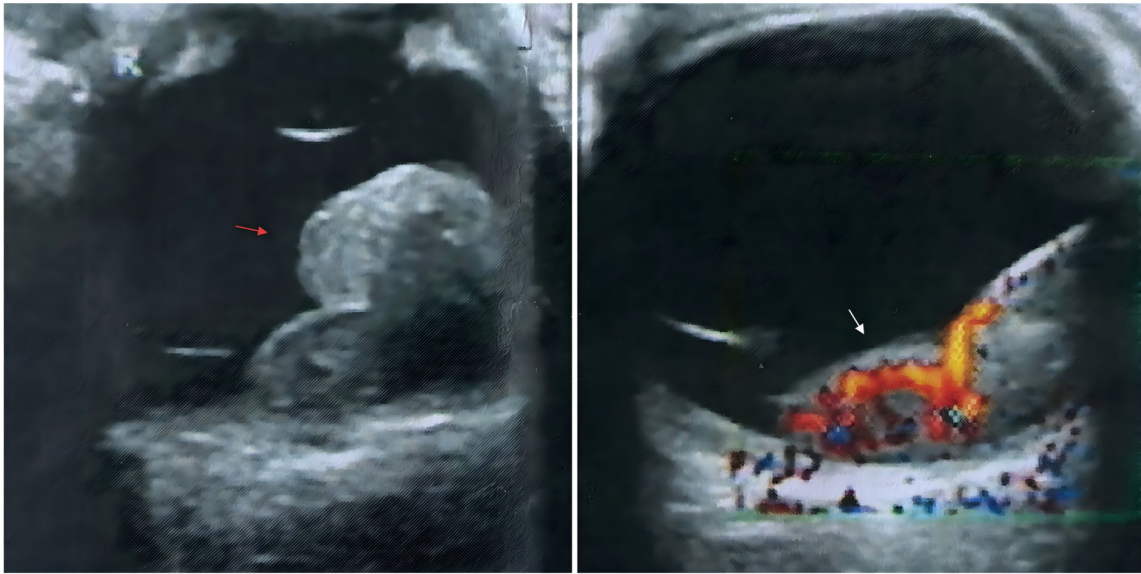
Ocular ultrasound at initial consultation shows ciliary body leakage and a low-to-medium echogenic solid mass on the fundus wall (red arrow), with irregular internal echoes and well-defined margins. A membranous bulge with abundant internal blood flow is observed (white arrow).
